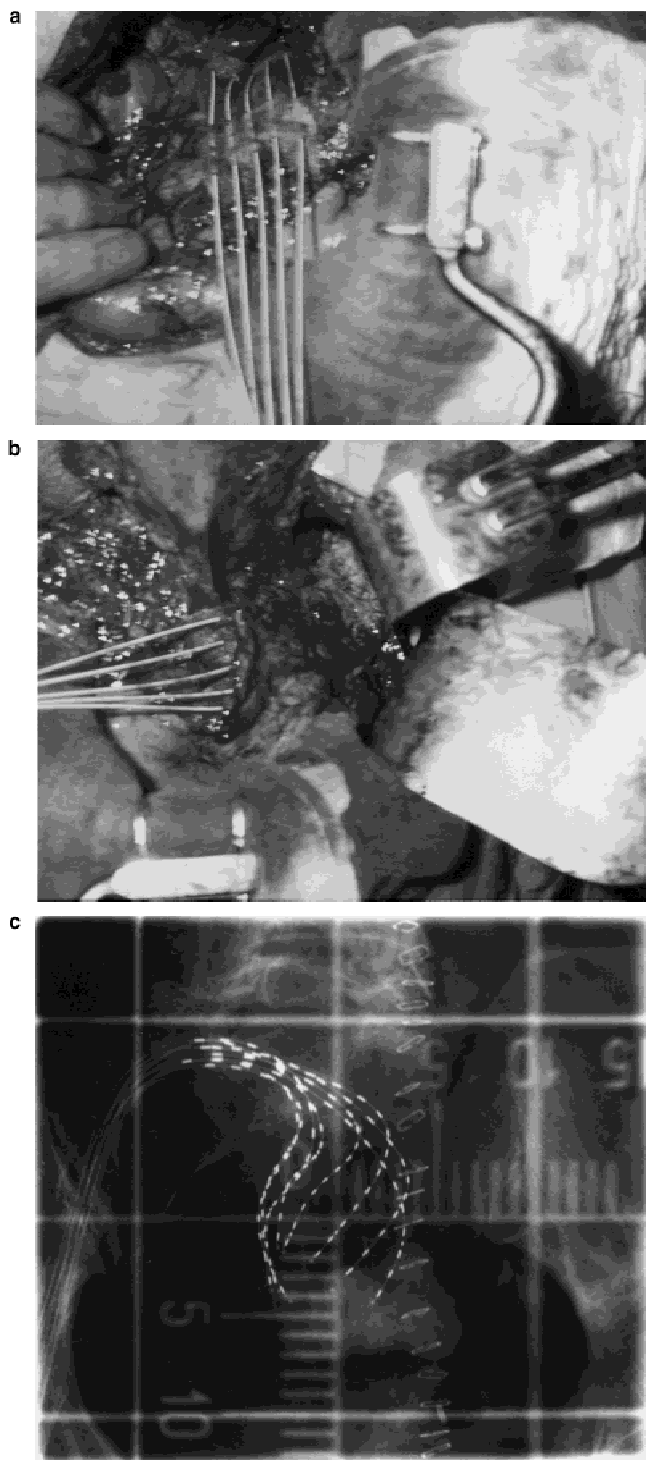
(a) Recurrent carcinoma of the sigmoid colon with dummy catheters in place for localization (Patient No. 4). (b) Omentum positioned over the implant to protect small bowel (Patient No. 4). (c) Radiograph of the mesh implant for the same case (Patient No. 4).
